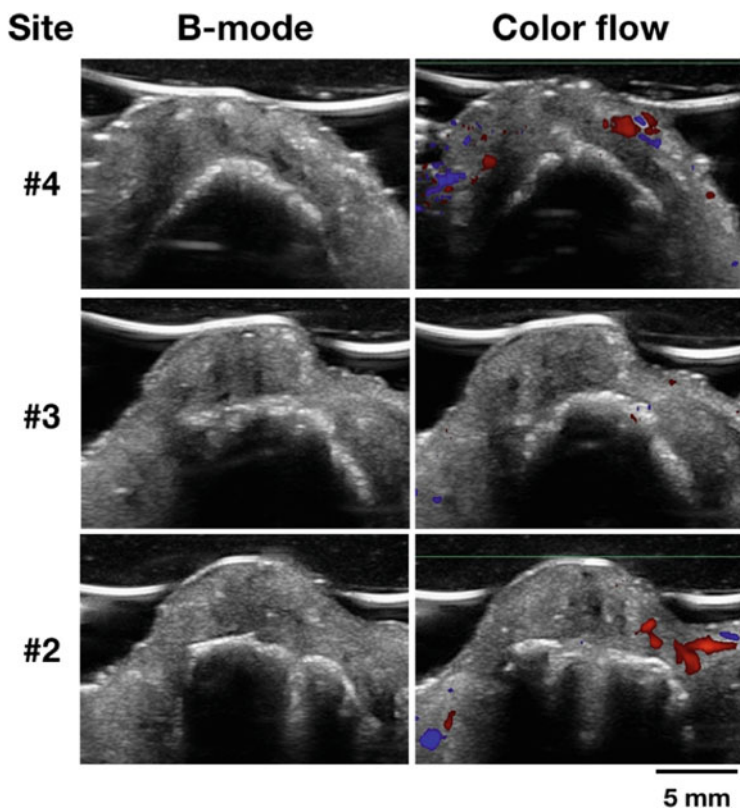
Ultrasound occlusal images of the same case at 2 months after the membrane was removed. On the B-mode images, soft tissue thickness and ridge width can be measured in preparation for the implant placement surgery. The edentulous ridge at tooth #2 location shows discontinuous crestal bone surface and a hyperechoic structure into the bone, indicating some soft tissue invagination into bone in this area. Color flow images show normal blood flow
